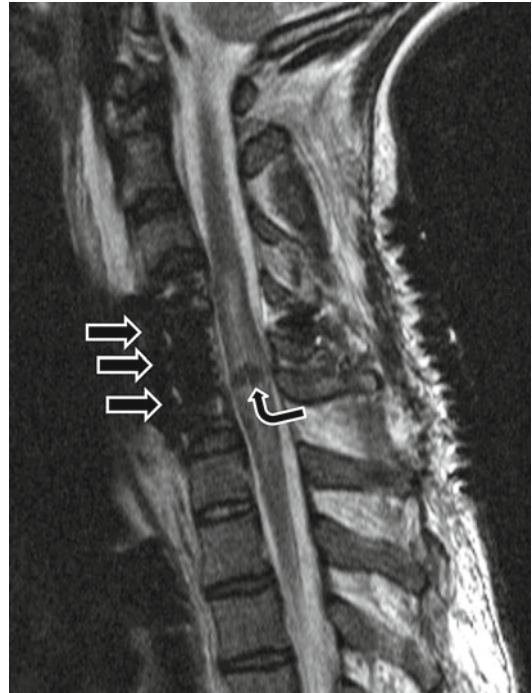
Sagittal T2-weighted image in same patient as Fig. 4.21, following emergent reduction and C4–C6 fusion with anterior fusion plate (*white arrows*). The MRI demonstrates spinal cord hemorrhage (low-signal focus, *curved arrow*) with surrounding edema. Cord hemorrhage connotes a poor neurologic prognosis
